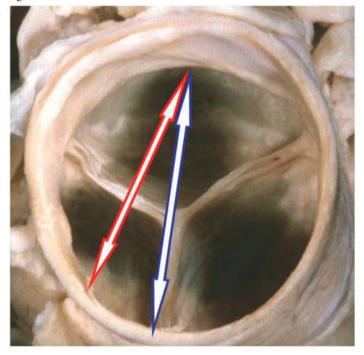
This basal short-axis view shows the closed aortic valve. The arrows demonstrate the potential hazard of 2-dimensional imaging techniques (echocardiography, contrast aortography) for measuring the "aortic valve annulus." Measurements made using the basal attachment of the leaflets do not transect the full diameter of the outflow tract but instead a tangent cut across the root. ¹⁸
